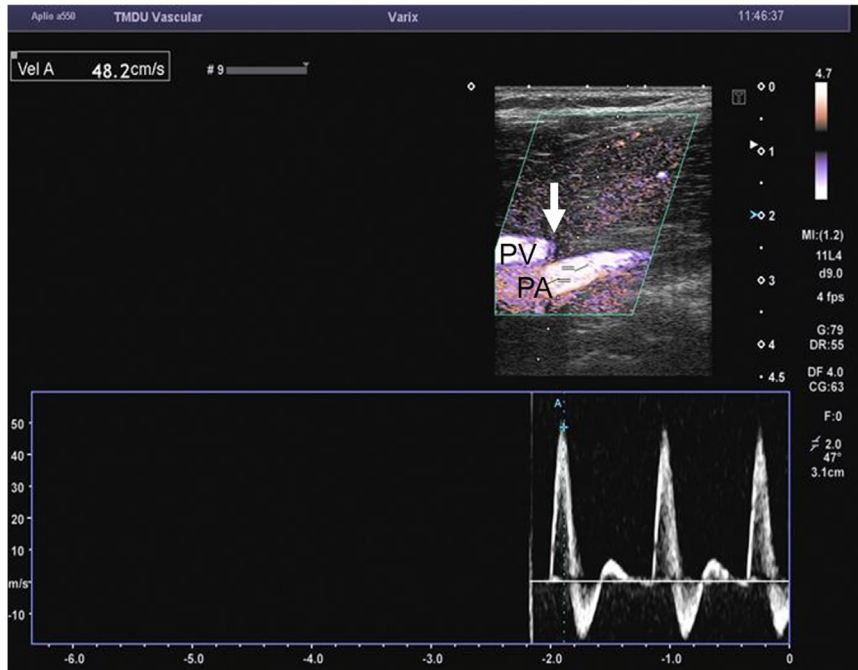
Color Doppler ultrasound image during knee extension with passive dorsiflexion of the ankle showing significantly reduced caliber of the popliteal vein (PV) and cessation of venous flow (arrow). Arterial flow remained unaffected. PA, Popliteal artery.
